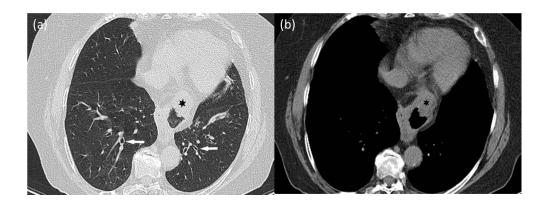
Axial computed tomography images
